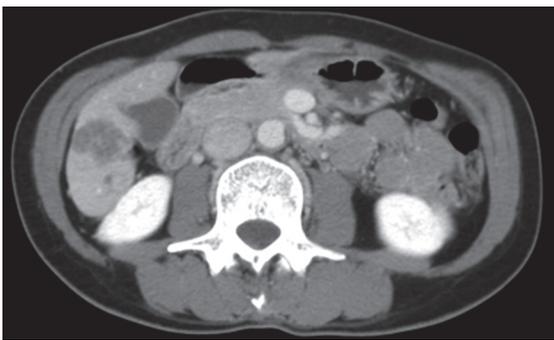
CT scan showing interval reduction in size to 2.9×3.6 cm after two cycles of OXAFI.
